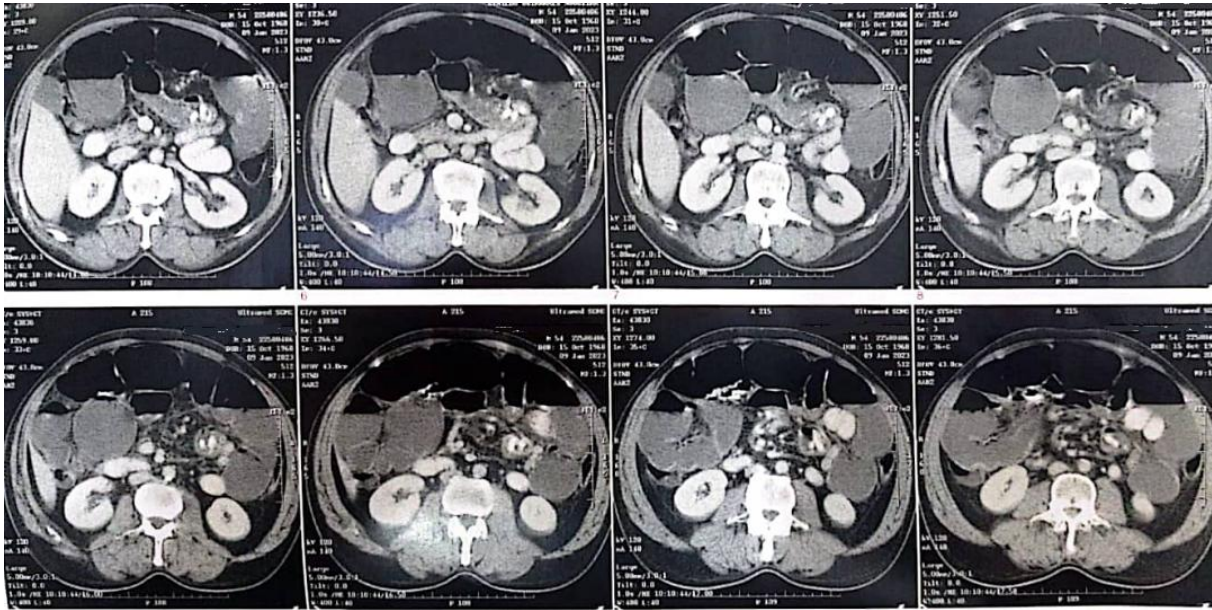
COMPUTED TOMOGRAPHY OF THE ABDOMEN, REVEALING BILATERAL LAMINAR PLEURAL EFFUSION AND MARKED DILATION OF SMALL BOWEL LOOPS, WITH AN APPARENT AREA OF CALIBER REDUCTION IN THE ILEAL LOOPS' TOPOGRAPHY. SMALL MESENTERIC LYMPH NODES ARE ALSO OBSERVED ON THE RIGHT FLANK, ADJACENT TO THE AREA OF APPARENT OBSTRUCTION, FOLLOWED BY MODERATE LIQUID DISTENSION OF THE COLIC SEGMENTS, WITHOUT SIGNS OF OBSTRUCTION.
